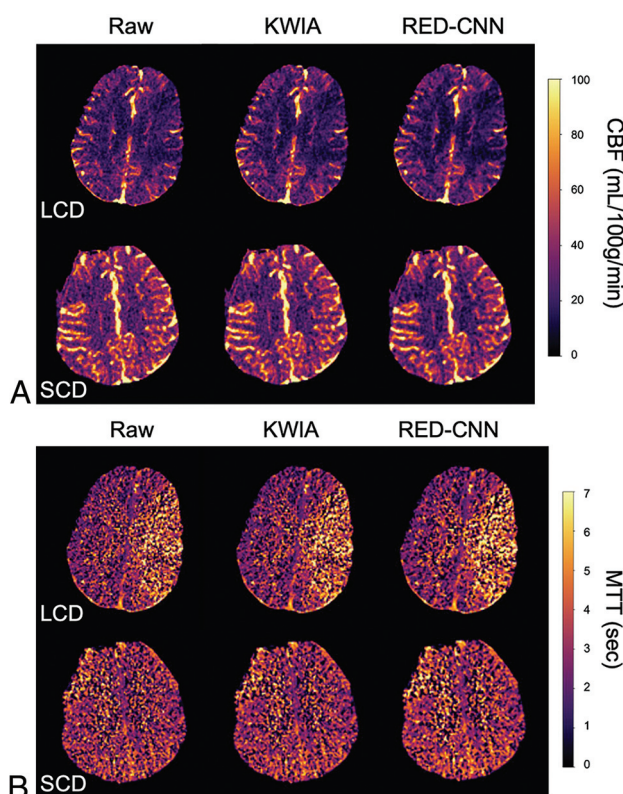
CTP maps of 67-year-old man with left MI MCA occlusion on CTA, presenting with right-sided weakness (LCD), and 61-year-old man with right MCA occlusion on CTA and left-sided weakness (SCD). Standard, KWIA-filtered, and RED-CNN denoised clinical CBF maps of representative LCD and SCD (A) and MTT maps of the same 2 patients (B), showing progressive, improved SNR with KWIA filtering and RED-CNN denoising, respectively.
